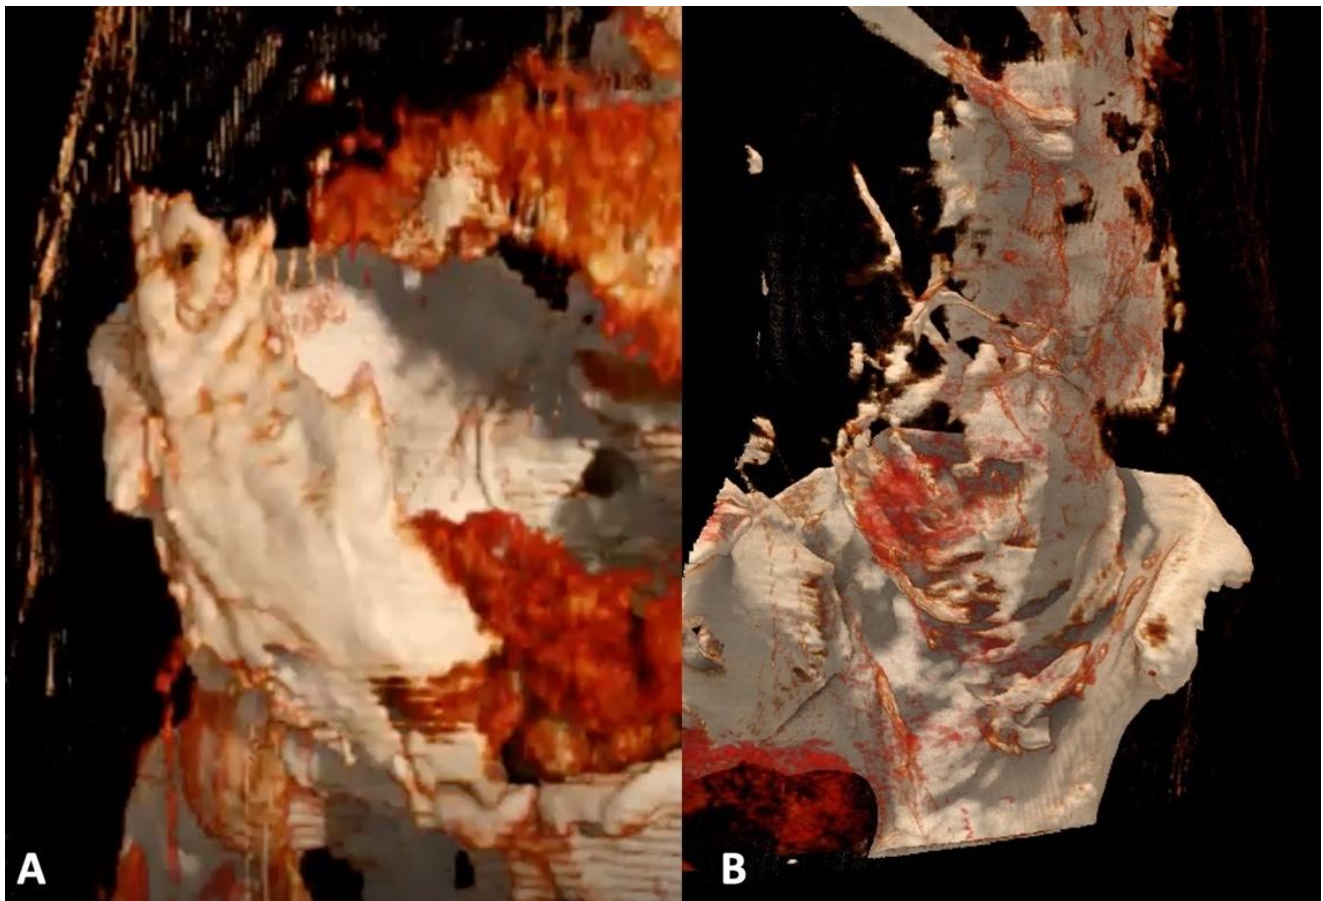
3D CT images of the drug spread. A: Spread on the right side (10 mL), B: Spread on the left side (20 mL)
